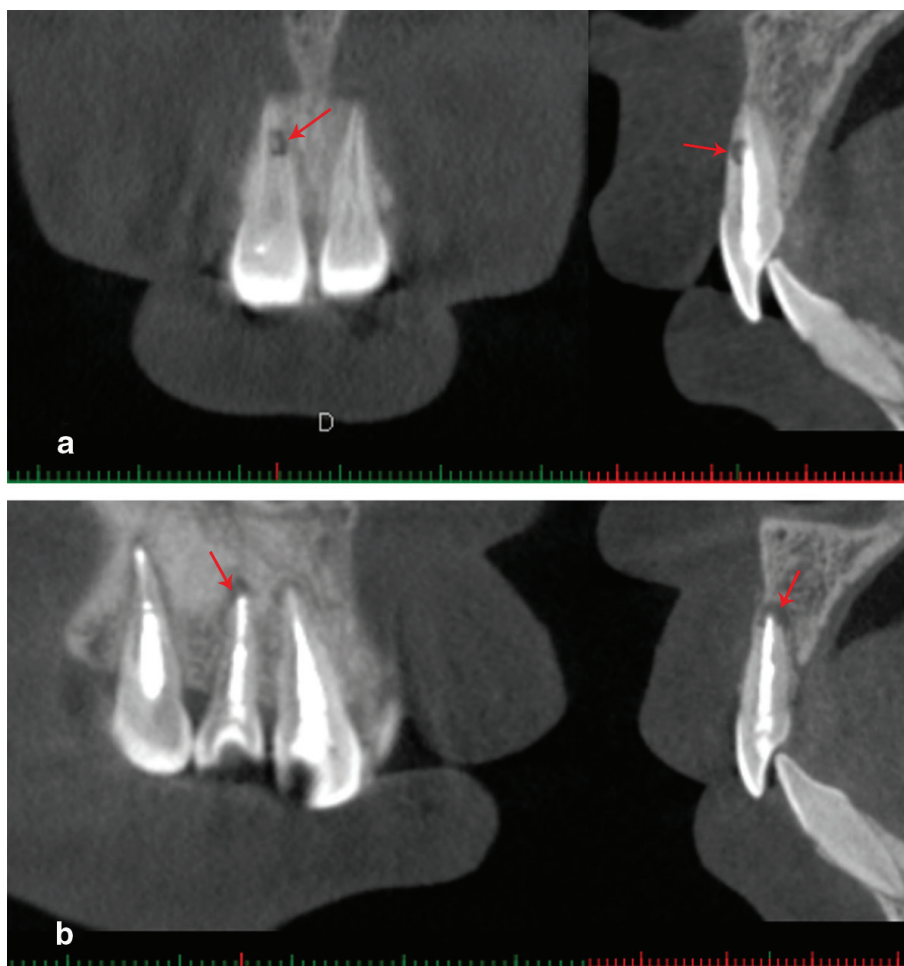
(a) CBCT scan showed an IRR lesion image in the lower 1/3 of the root of the affected tooth 11; (b) CBCT scan showing an IRR lesion image in the apex of the root of the affected tooth 12.
